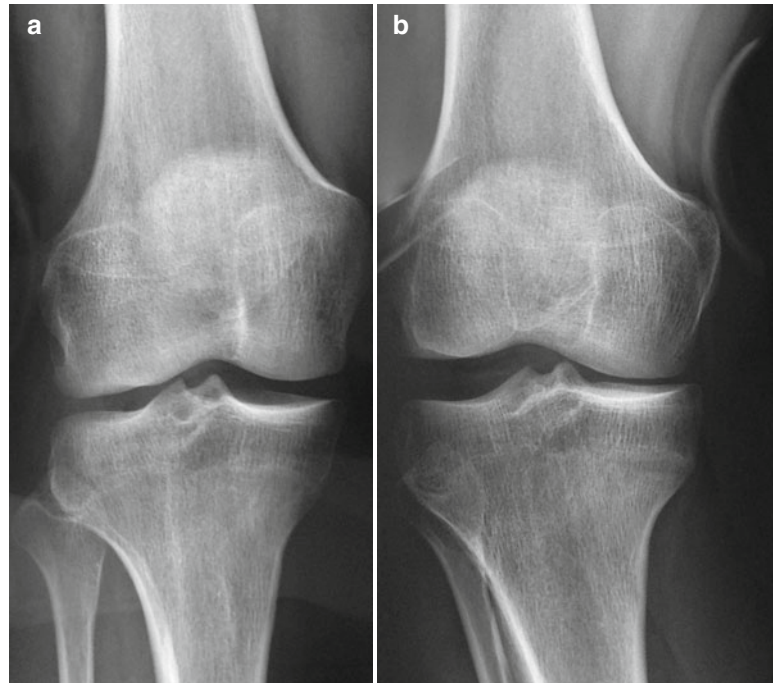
(a) Plain anteroposterior radiograph and (b) stress view demonstrating lateral ligament insufficiency in the setting of chronic ACL deficiency
